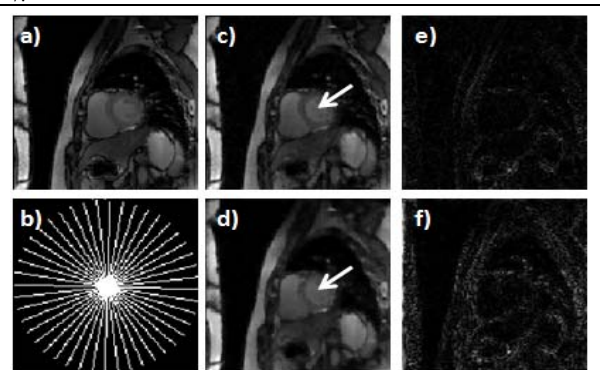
Reconstruction results with 22 lines: a) first time frame of the original free breathing cardiac MR images; b) radial undersampling trajectory; c) reconstruction with proposed scheme with SER 9.98 and the error is plotted in e); d) TV reconstruction with SER of 8.87 and the error is plotted in f). Noted that the TV scheme blurred the image.
